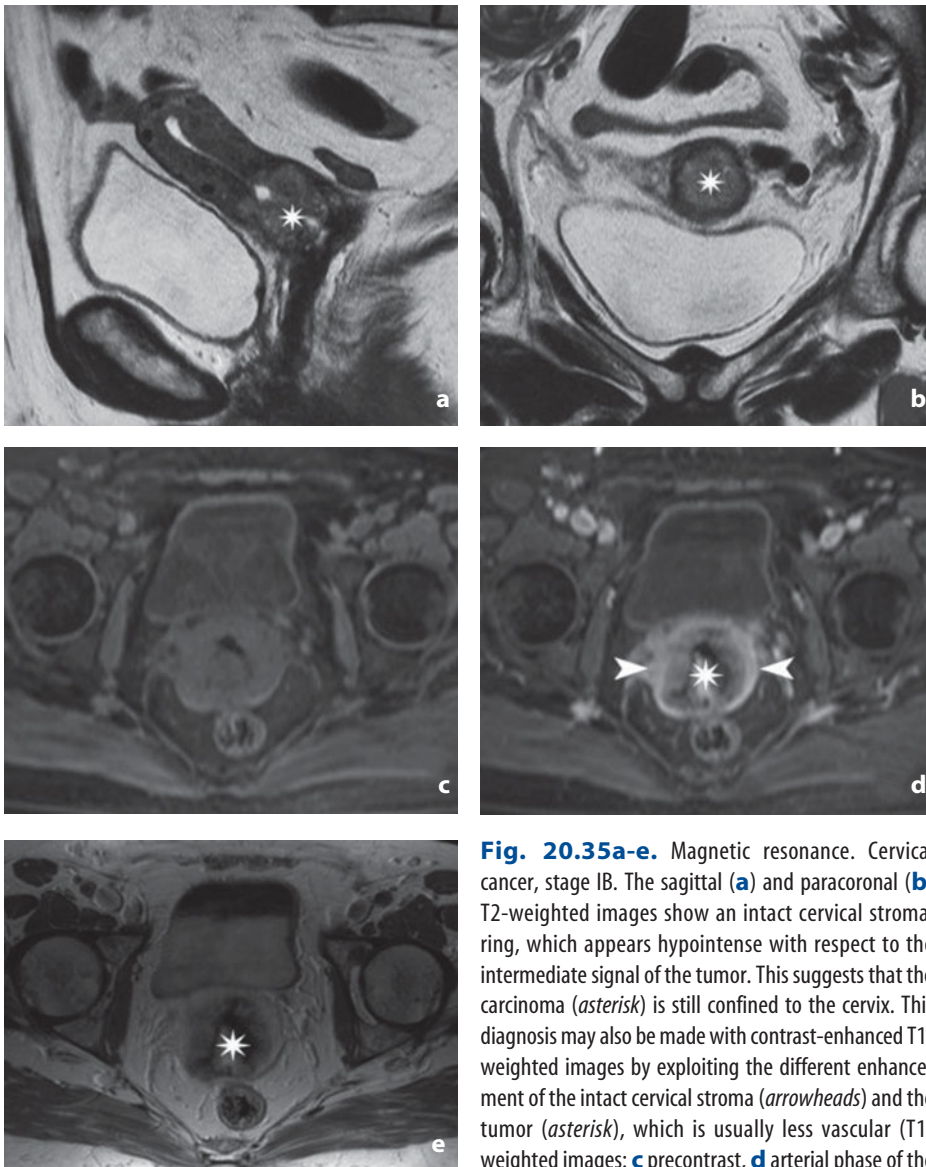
Magnetic resonance. Cervical cancer, stage IB. The sagittal (a) and paracoronal (b) T2-weighted images show an intact cervical stromal ring, which appears hypointense with respect to the intermediate signal of the tumor. This suggests that the carcinoma (*asterisk*) is still confined to the cervix. This diagnosis may also be made with contrast-enhanced T1-weighted images by exploiting the different enhancement of the intact cervical stroma (*arrowheads*) and the tumor (*asterisk*), which is usually less vascular (T1-weighted images: c precontrast, d arterial phase of the dynamic study, e late phase)
